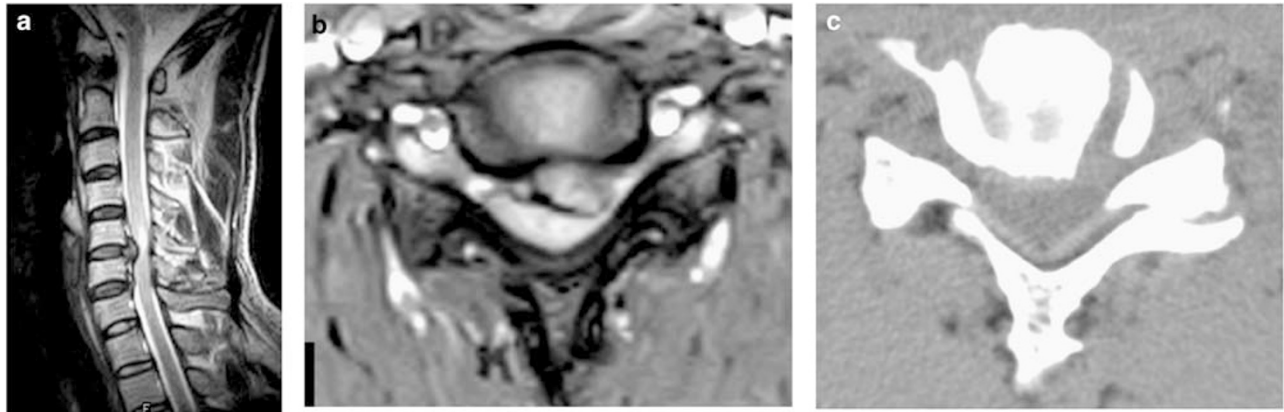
Preoperative T2-weighted sagittal (a) and axial (b) MR images in Case 2 demonstrating a large left paramedian disc herniation at the C5–C6 level, with ipsilateral severe spinal cord compression and high-signal intensity within the spinal cord adjacent to the herniated disc. Postoperative axial CT image (c) revealing complete decompression of the spinal cord through a small tunnel
